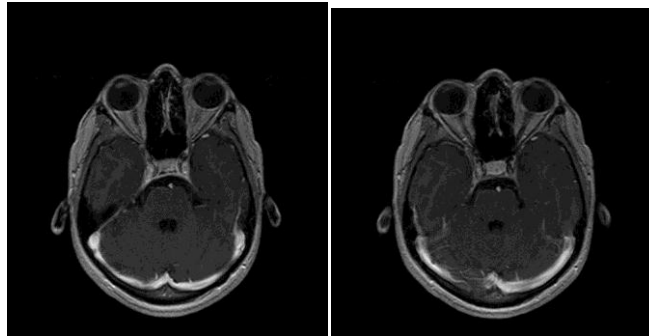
MR image before segmentation
